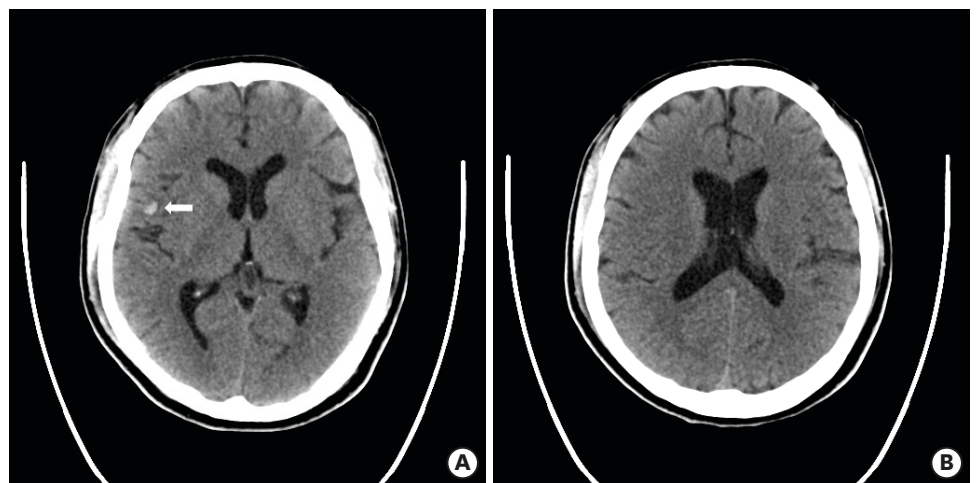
Repeat cranial computed tomography scan obtained 3 days after the injury reveals that the traumatic intracerebral hemorrhage still persisted in the right temporal lobe (white arrow) and traumatic intraventricular hemorrhages completely resolved.
